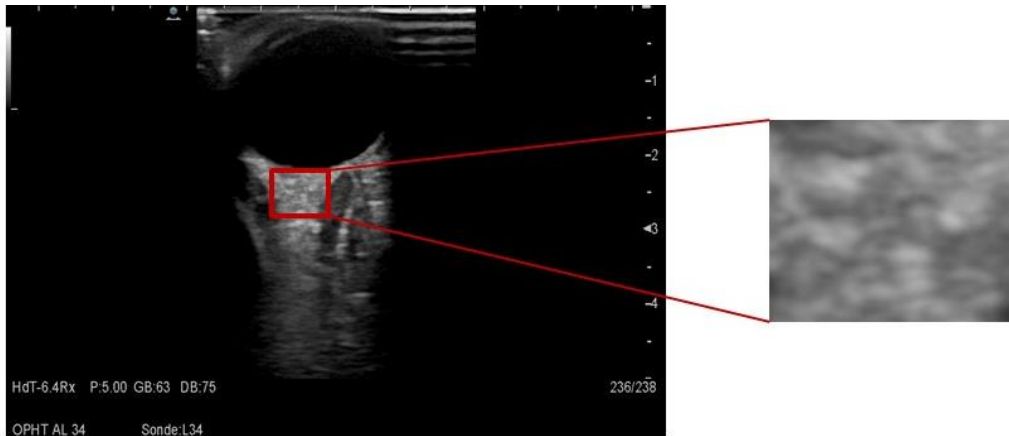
Zoom on the speckle of a conventional ultrasound image of an eye [Courtesy of Pr. Anne Long, Hôpital Edouard Herriot, Lyon, France]
